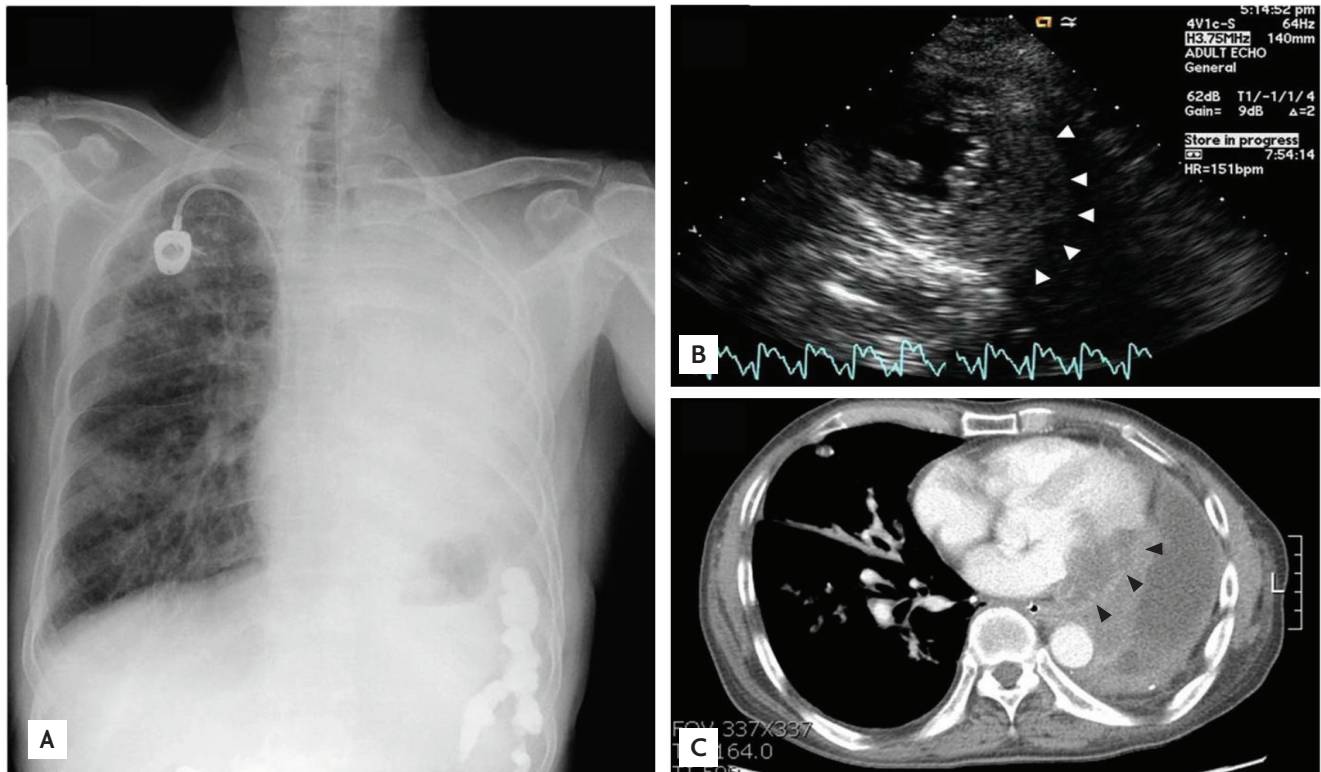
(A) Chest X-ray at admission showed diffuse increased haziness in the entire left lung fields due to a previous left pneumonectomy. (B) Echocardiography revealed thickening of the lateral wall of the left ventricle (arrowheads) with a heterogeneous echo-texture. (C) Computed tomography revealed abnormal heterogeneous thickening of the lateral wall of the left ventricle (arrowheads) infiltrating the left lung mass.
